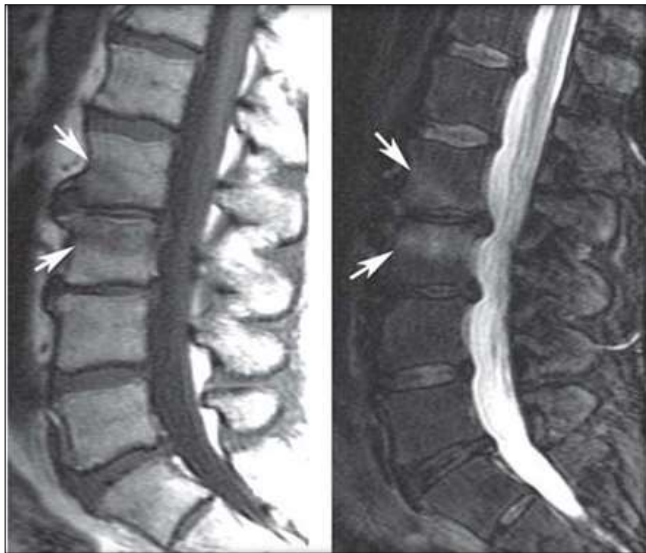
Sagittal T1-weighted (A) and fat-suppressed T2-weighted (B) images showing the typical pattern (arrow on each) of decreased signal intensity on the L1-L2 Level
